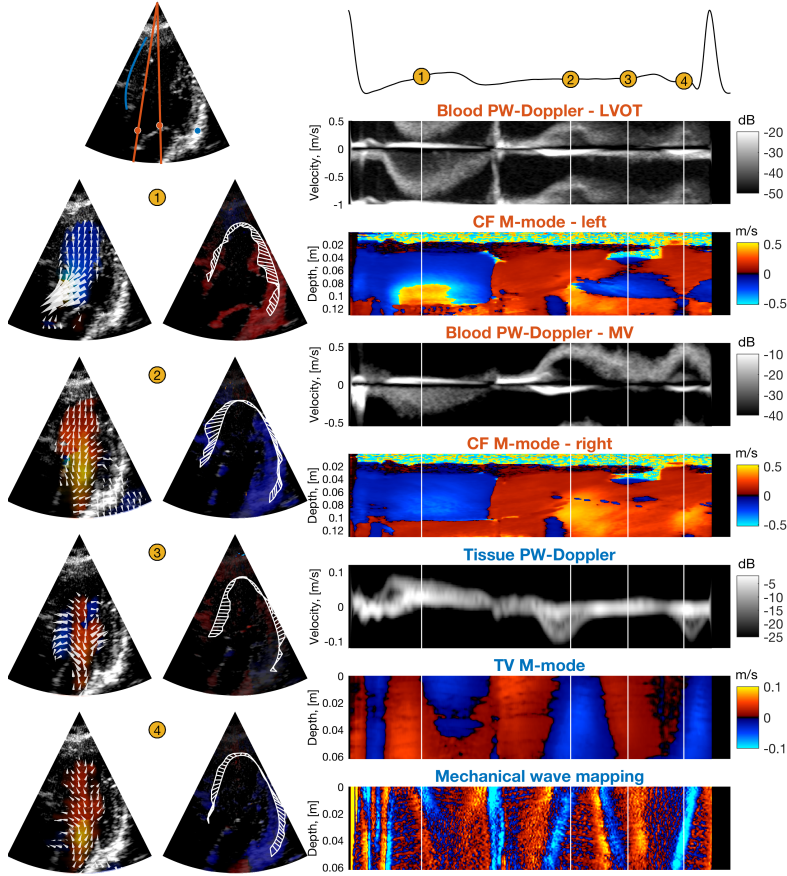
Figure showing different modes calculated from one acquisition. The top right image shows locations for the temporal images to the right: red line shows color M-mode position, red dot is the blood PW Doppler. The blue line is for anatomic tissue M-mode and mechanical wave mapping. The blue dot represents the spatial position for tissue PW Doppler. The two leftmost columns shows image data for flow and tissue, respectively, with color/tissue Doppler background and vector velocity estimates drawn as arrows and lines.
